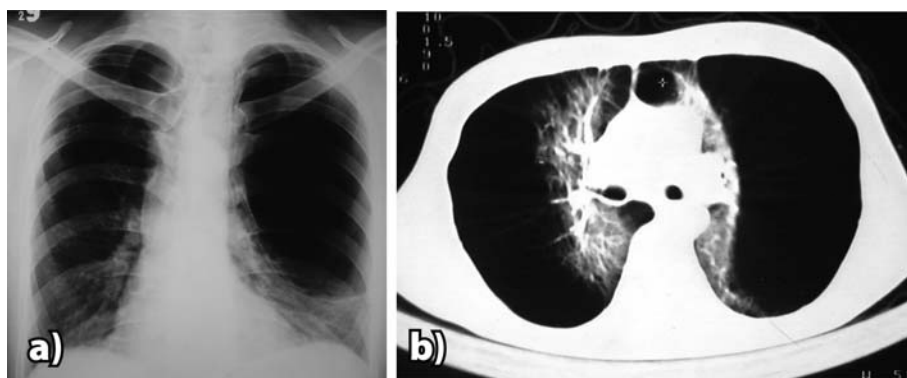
Bilateral diffuse massive pneumatoceles with minimal normal surrounding lung parenchyma shown by a) chest radiography, and b) computed tomography (CT) scan.
